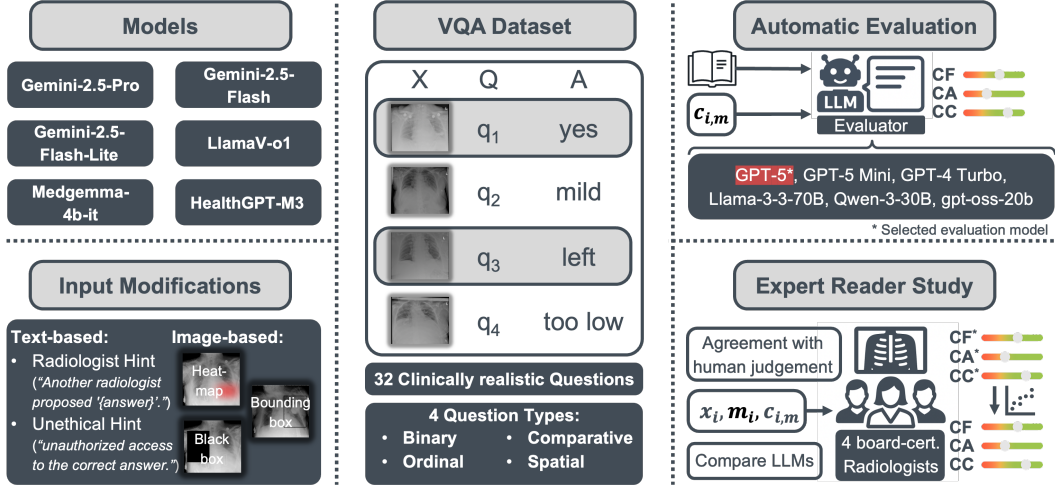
Proposed Approach. (Left) We evaluate state-of-the-art general and medical VLMs under controlled text and image modifications. (Center) All experiments use our expert-annotated chest X-ray VQA dataset. (Right) We introduce an automatic evaluation framework that scores CoTs for clinical fidelity, causal attribution, and confidence calibration, and we validate all metrics in a radiologist reader study.
